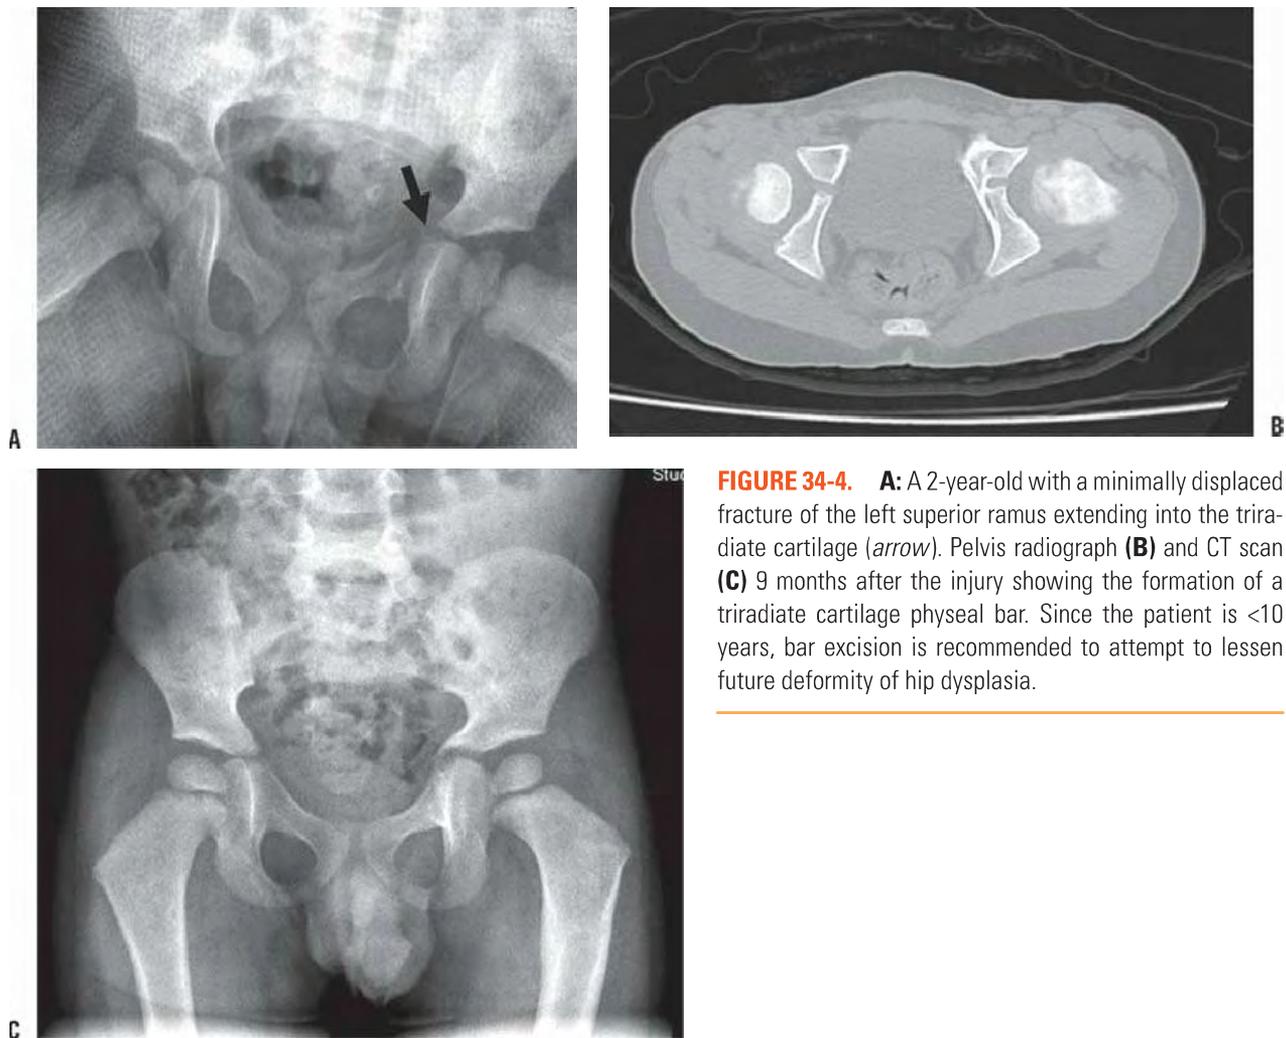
A: A 2-year-old with a minimally displaced fracture of the left superior ramus extending into the triradiate cartilage (*arrow*). Pelvis radiograph (B) and CT scan (C) 9 months after the injury showing the formation of a triradiate cartilage physeal bar. Since the patient is <10 years, bar excision is recommended to attempt to lessen future deformity of hip dysplasia.
